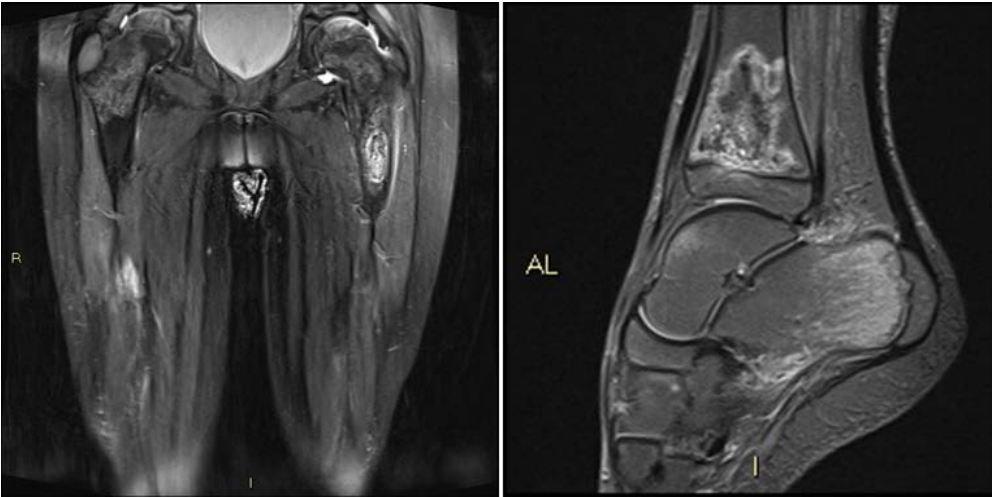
Radiographic image of a 10-year-old girl with history of glucocorticoid treatment for ALL, with multifocal lower extremity pain. T2-weighted MRI images of bilateral femurs and left ankle show evidence of widespread osseous infarcts.
